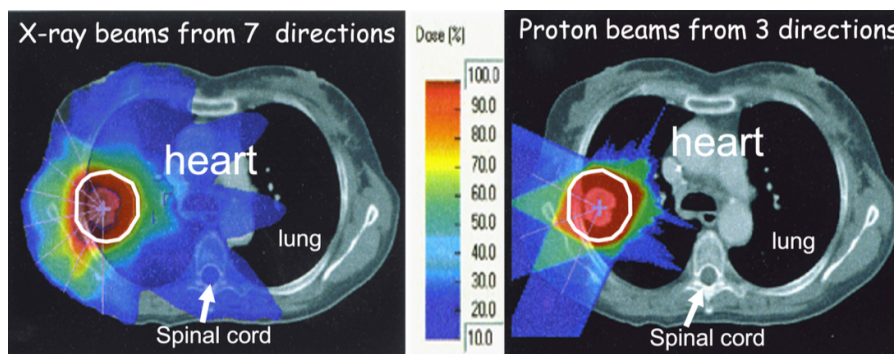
Comparison of dose distributions for a lung tumour irradiation with X-rays from seven angles (left) and with proton beams from three angles (right) (Auberger et al., 2004).
